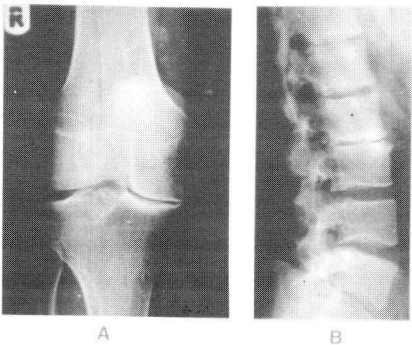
Roentgenographs of individual III-1 at age 53 years A) right knee joint demonstrating marked OA medially and chondrocalcinosis laterally, without evidence of epiphyseal dysplasia. B) lumbosacral spine joints (lateral view) demonstrating osteophytosis and disc degeneration at level L2-L3. No dysplastic features.
